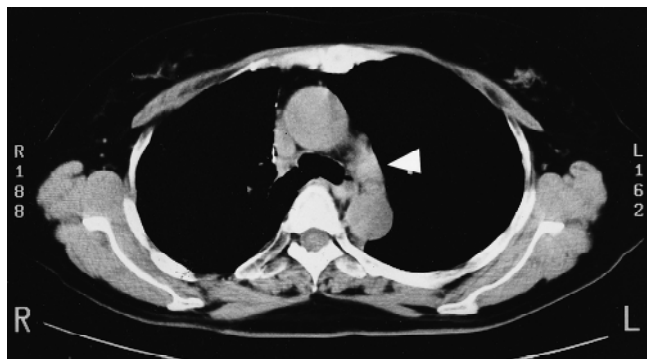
A swollen lymph node in the aortopulmonary window was detected by computed tomography (CT) 4 months after the operation. This is a plain CT film; the *arrow* points to the swollen lymph node (12 mm in diameter)
